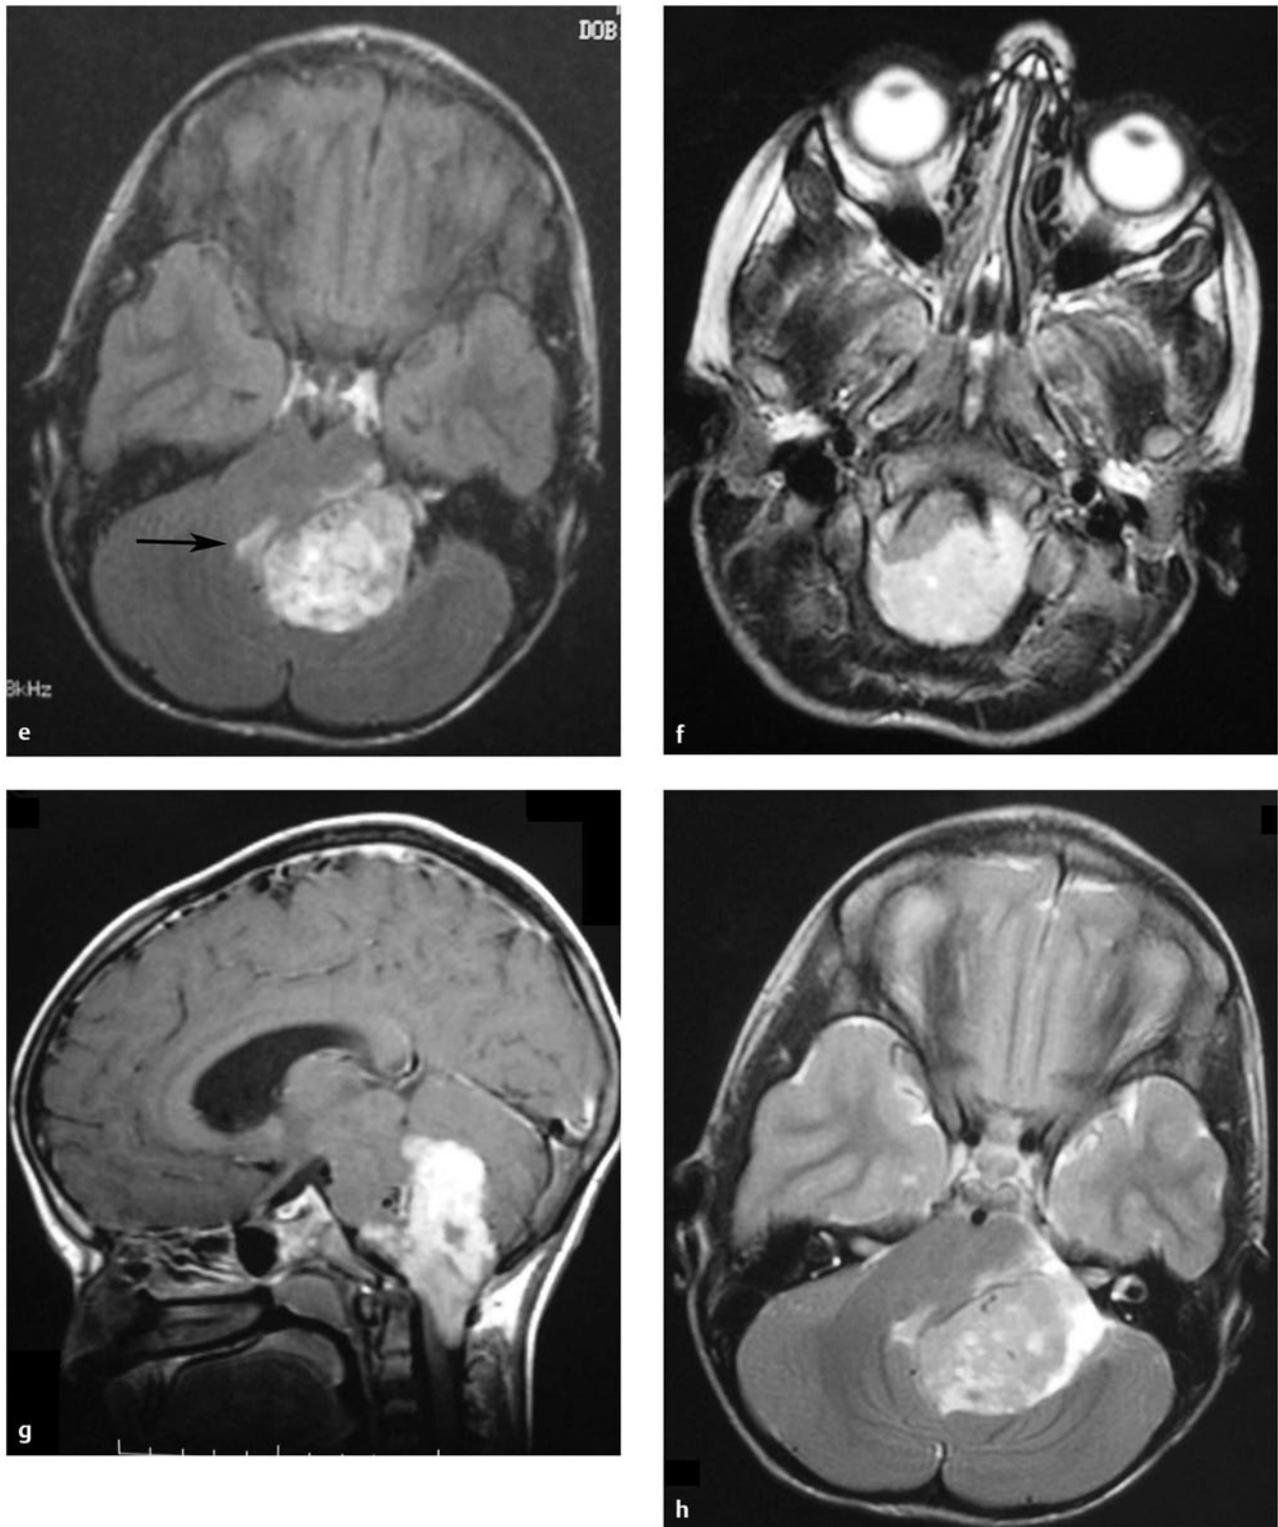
(continued) (e) Partially enhancing, partially nonenhancing tumor around the lower brainstem. (f) Sagittal T1-weighted MR image with gadolinium shows enhancing tumor extending out into the CPA, as well as extending down into the cervical spinal canal. (g) Axial T2-weighted MR image shows a hyperintense lesion extending out of the foramen of Luschka on the left. (h) Axial T2-weighted MR image shows the mass effect on the brainstem, with the tumor, extending up to the basilar artery.
